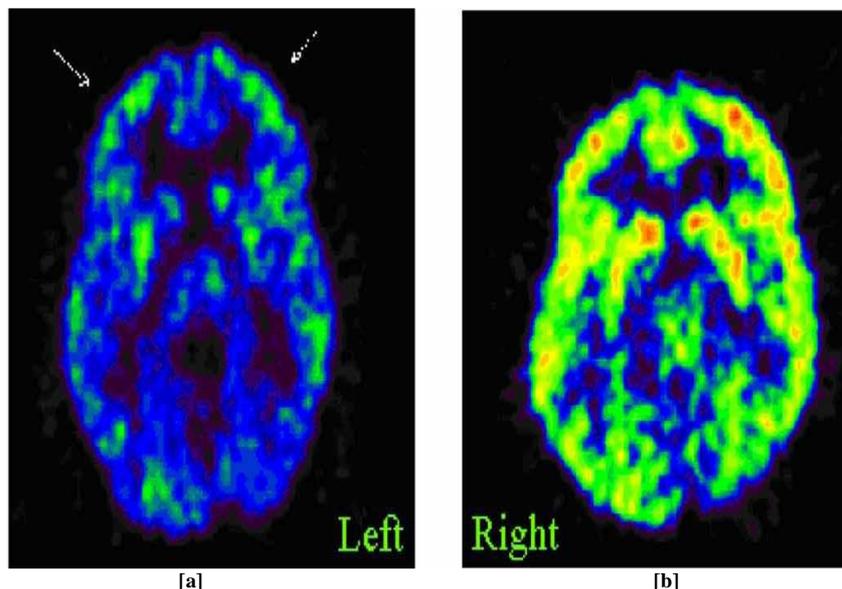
PET-FDG scans demonstrating a comparison between a control patient with no depression [a] and a clinically depressed patient [b]. The blue color represents less activity (glucose metabolism) while the green represents more activity (glucose metabolism).
